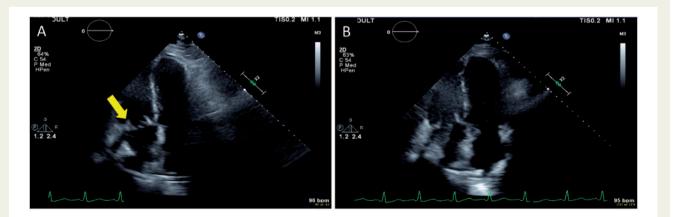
Postoperative transthoracic echocardiogram apical 4 chamber view showing: (A) bioprosthetic tricuspid valve (yellow arrow), (B) negative bubble study post-surgical closure of patent foramen ovale.
